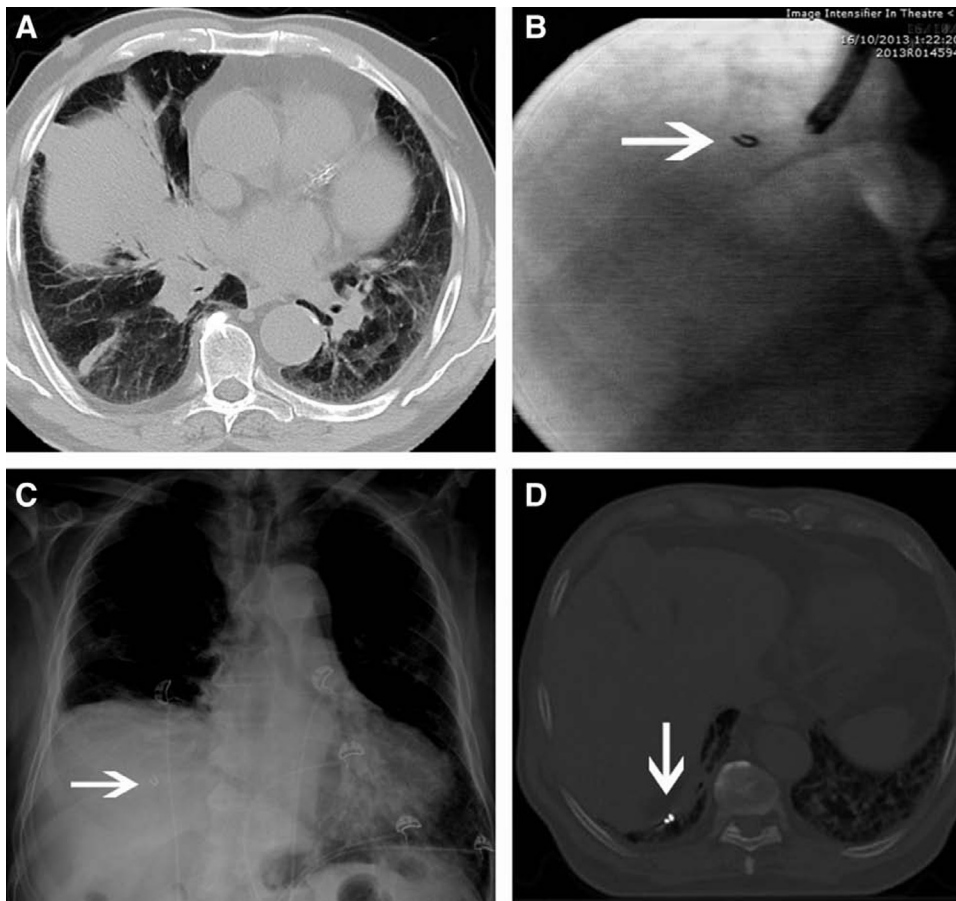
A, Fluoroscopic imaging demonstrating placement of fiducial marker targeting the (B) right mid-zone tumor seen on CT chest. C, CXR demonstrates apparent inferior migration of marker to lung base, confirmed on (D) postimplantation planning CT. CT, computed tomography; CXR, chest x-ray.
